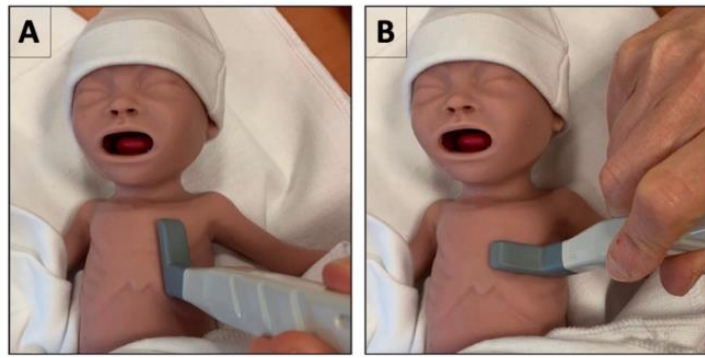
Probe position for neonatal lung ultrasound. Panel A shows the vertical longitudinal scan, and Panel B shows the horizontal transcostal scan. Adapted from [54].
